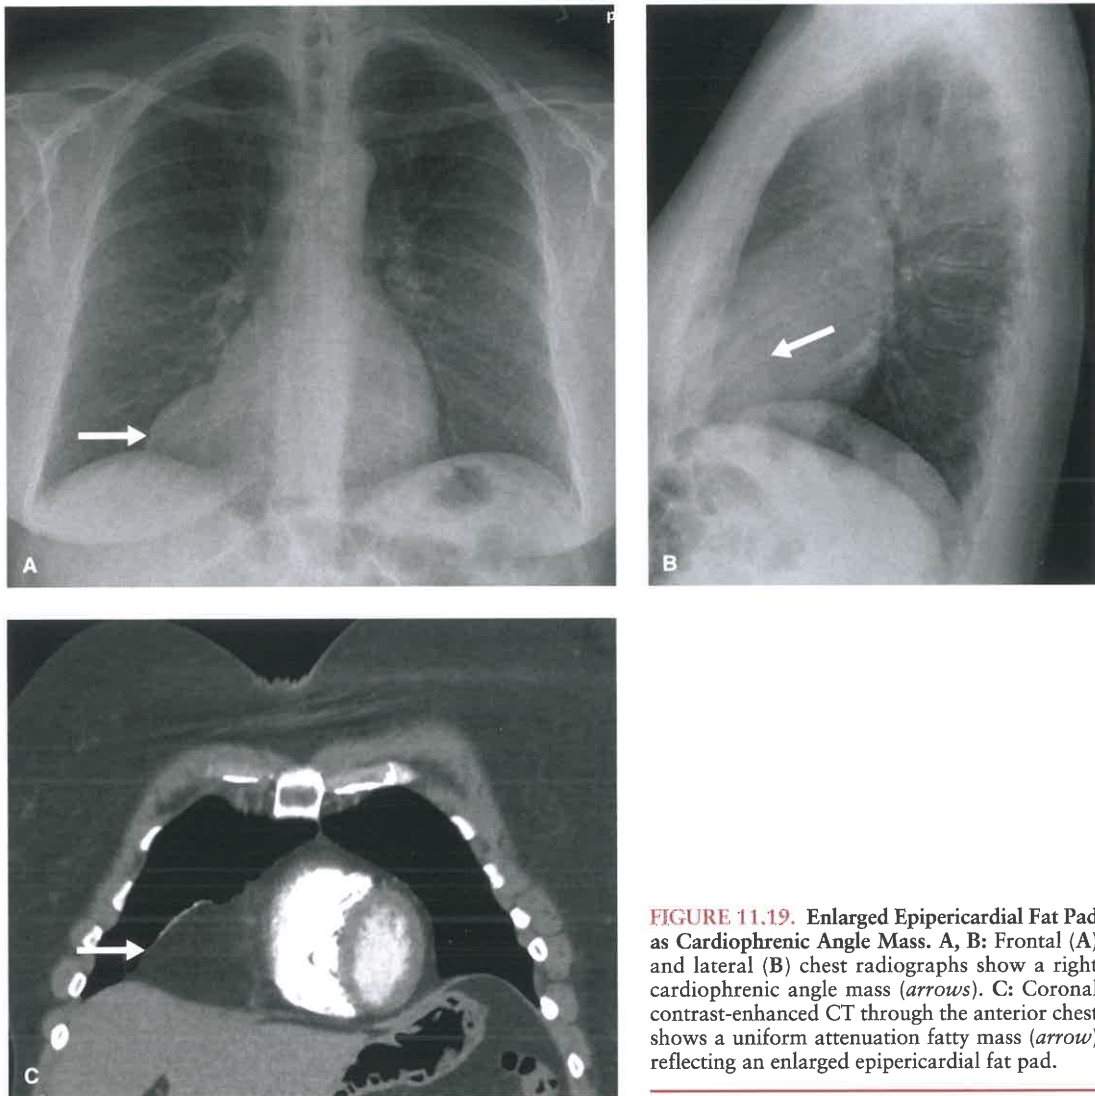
Enlarged Epipericardial Fat Pad as Cardiophrenic Angle Mass. A, B: Frontal (A) and lateral (B) chest radiographs show a right cardiophrenic angle mass (arrows). C: Coronal contrast-enhanced CT through the anterior chest shows a uniform attenuation fatty mass (arrow) reflecting an enlarged epipericardial fat pad.
